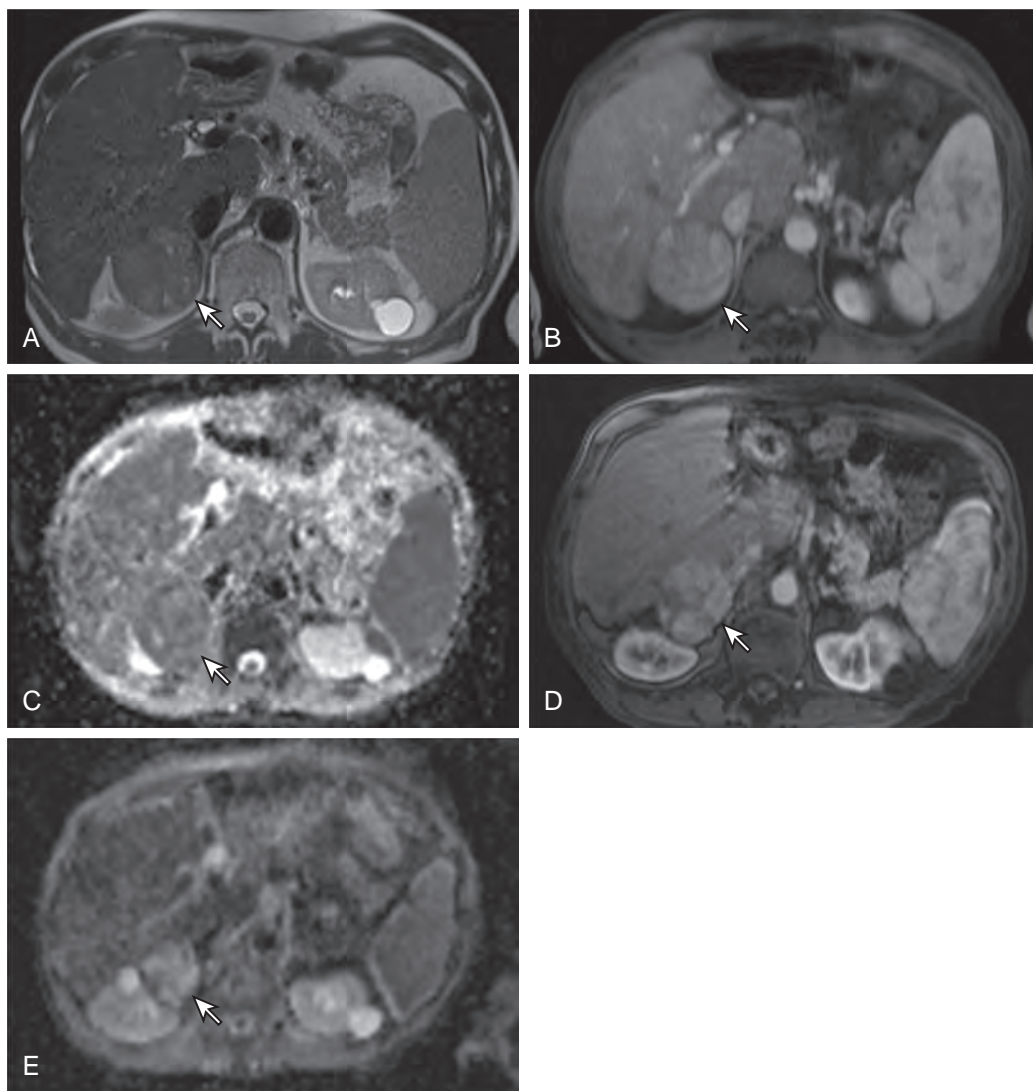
Use of diffusion-weighted MRI to predict treatment response. A. T2-weighted image shows an exophytic mass from the right lobe of the liver (arrow). B. T1-weighted postcontrast image reveals that this mass enhances; it was found to be a hepatoma (arrow). C. Diffusion-weighted MRI reveals low signal, suggesting restricted diffusion (arrow). D. MR image early after radioembolization shows some persistent enhancement (arrow). E. Diffusion-weighted MR, however, reveals increased signal and less restricted diffusion (arrow), which suggests a favorable response to radioembolization despite the persistent enhancement. The diffusion images were able to predict a positive response before the contrast images.
